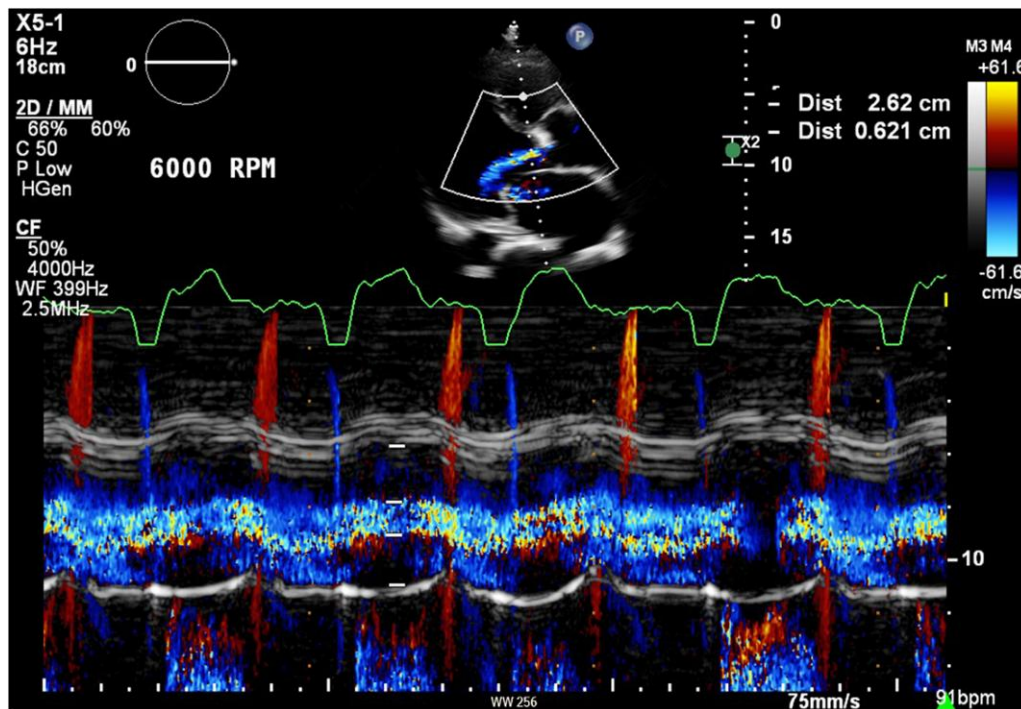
M-mode echocardiography and colour Doppler application for the evaluation of aortic regurgitation in patient with LVADs: this figure shows pan-cardiac cycle aortic regurgitation in a patient with HeartMate 3.
